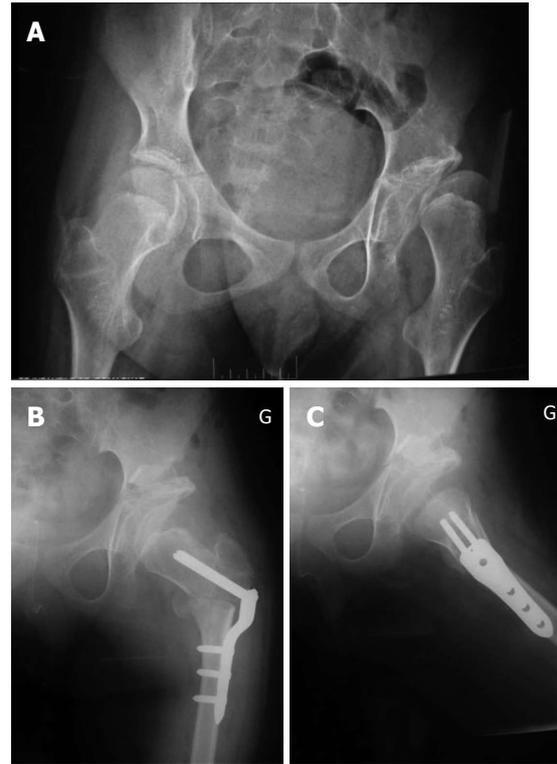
Pre (A) and post-operative operative antero-posterior (B) and lateral (C) radiographs of the pelvis (male patient, open triradiate cartilage).
